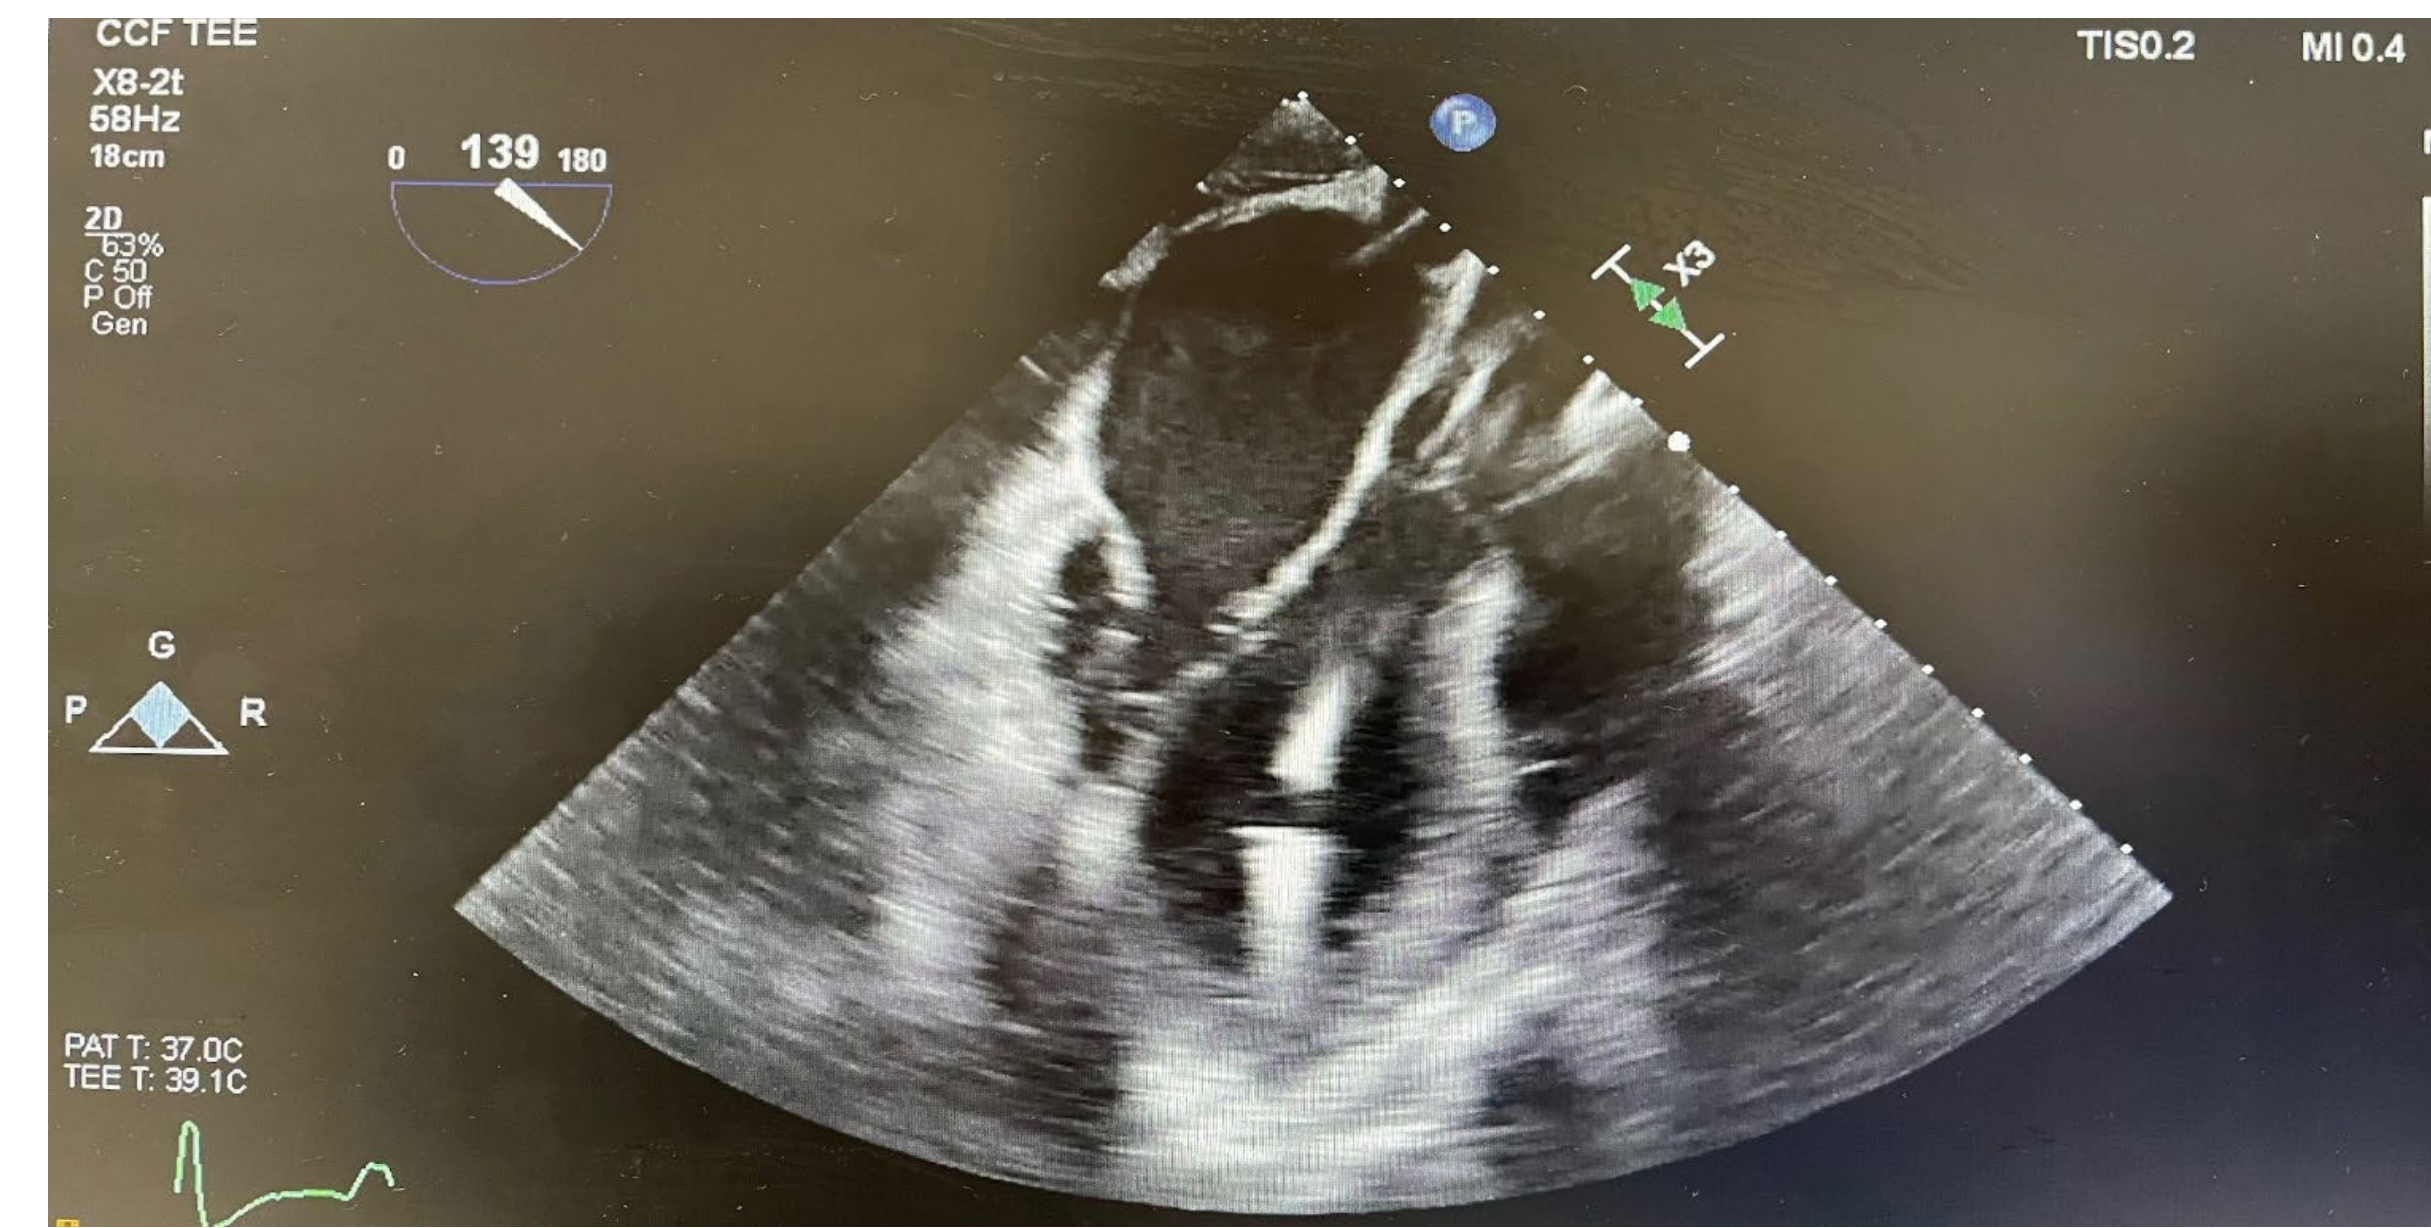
Transesophageal echocardiogram showing placement of Impella 5.5
